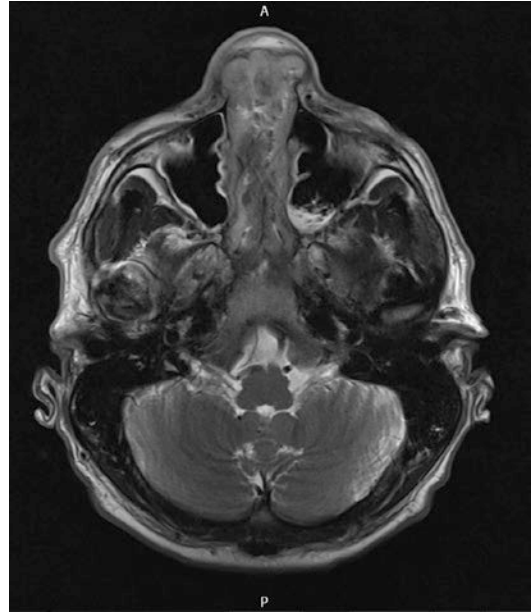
Axial MRI demonstrating the extent of the pathology
